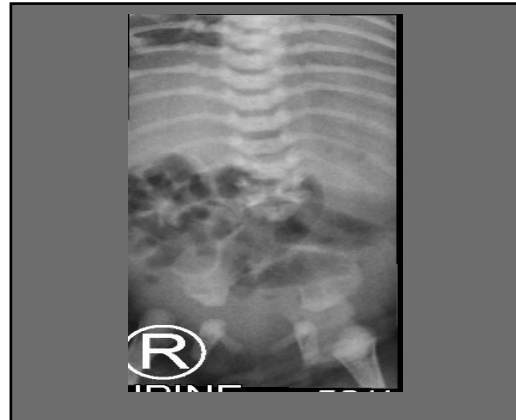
AP view of lumbosacral xray
